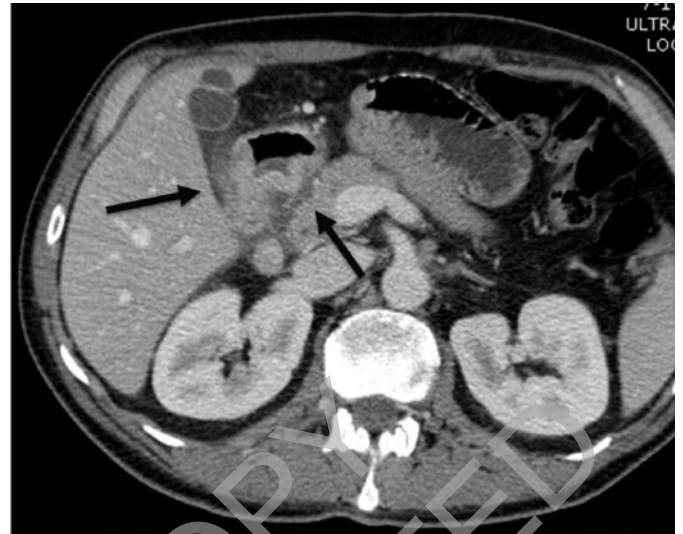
Case 1. CT scan showing a thickened duodenal wall with hypo-intensity of a widened groove between the head of the pancreas and of the duodenum (arrows).
